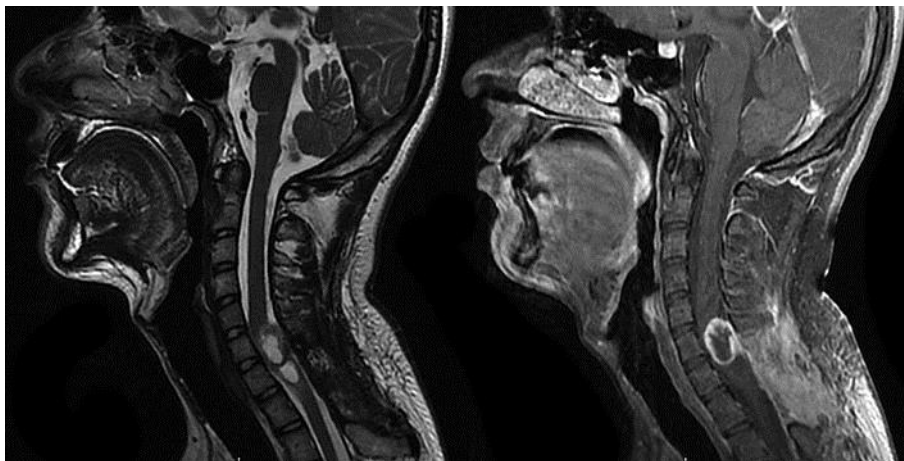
T2 (left) and T1-gadolinium (right) MRI showing a cervical intramedullary tumor.
